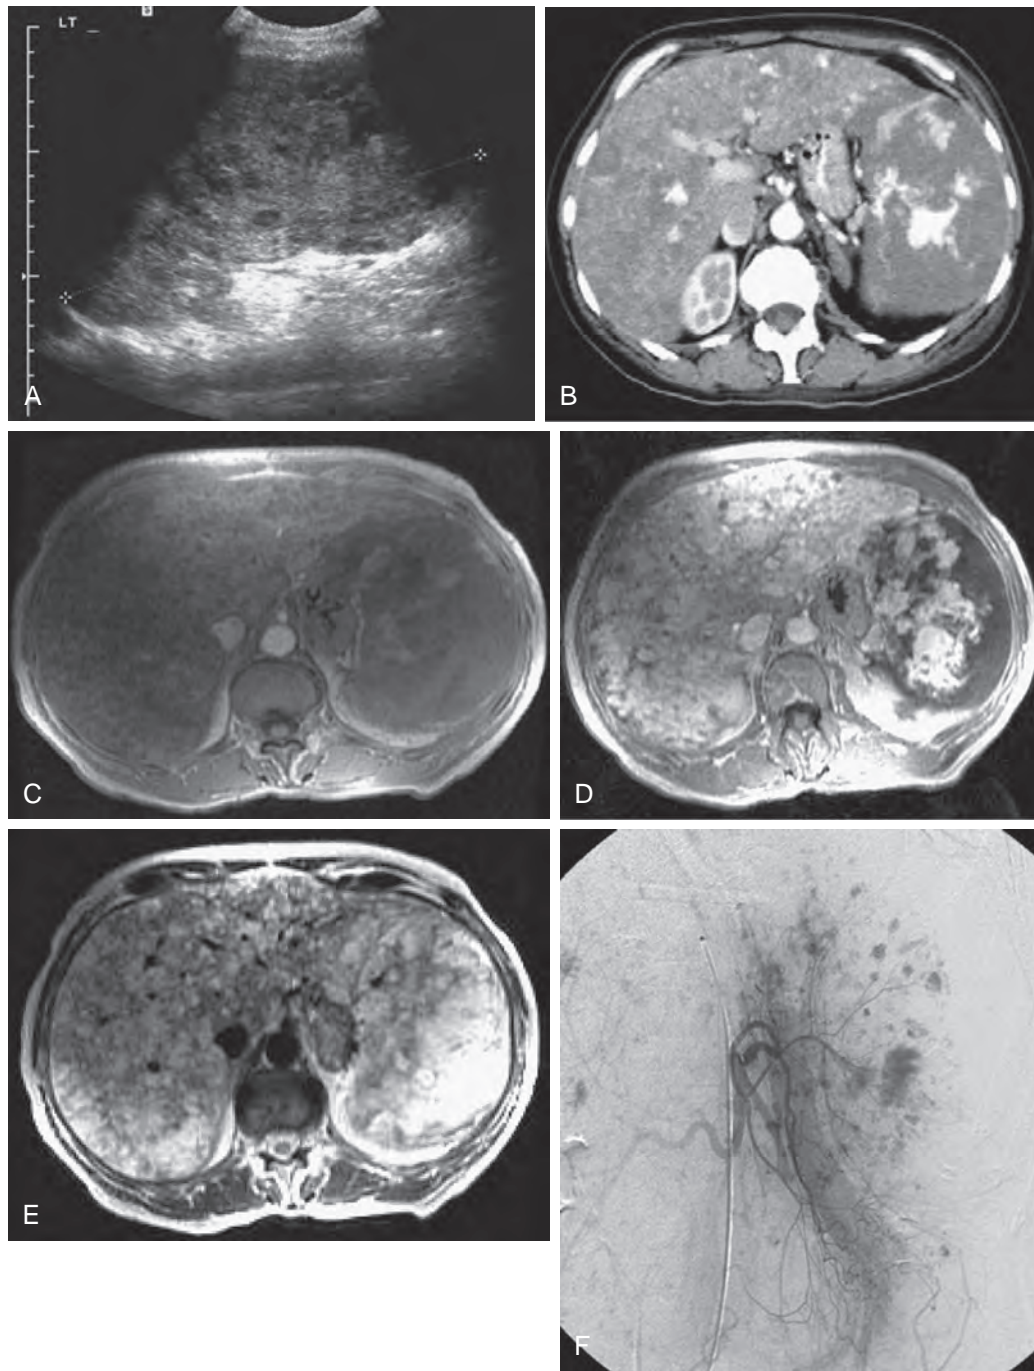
Angiosarcoma of the liver and spleen. A 62-year-old woman had a history of increasing upper abdominal pain on the left side, hepatosplenomegaly, pleural effusions, and coagulopathy. A. Ultrasound demonstrates a markedly enlarged spleen containing many ill-defined echogenic masses and hypoechoic areas. B. CT after intravenous administration of contrast material in the arterial phase shows a large, hypodense spleen with multiple areas of irregular enhancement and smaller similar lesions in the liver. C. T1-weighted image (FAME technique) at the same level reveals an enlarged spleen with ill-defined areas of decreased signal intensity relative to the surrounding spleen and areas of increased signal intensity (presumably hemorrhage). Multiple, small, hypointense lesions in the liver are also seen. D. Gadolinium-enhanced, T1-weighted MR image (FAME technique) at the corresponding level demonstrates an irregular central enhancement pattern and numerous enhancing lesions throughout the liver. E. The corresponding T2-weighted image (fast relaxation fast spin-echo = 3050/100 ms) demonstrates intrasplenic and intrahepatic masses with increased signal intensity. F. Pre-embolization angiogram during the early arterial phase shows splenomegaly, multiple hypervascular splenic masses, and vascular lakes.
